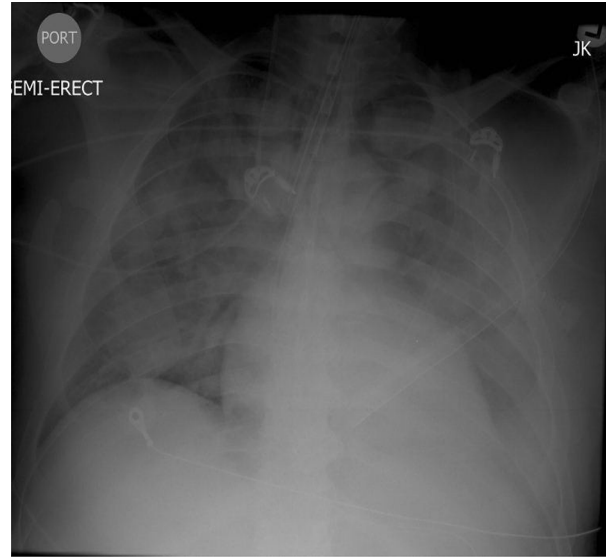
Chest radiography showing bilateral pulmonary infiltrates.
